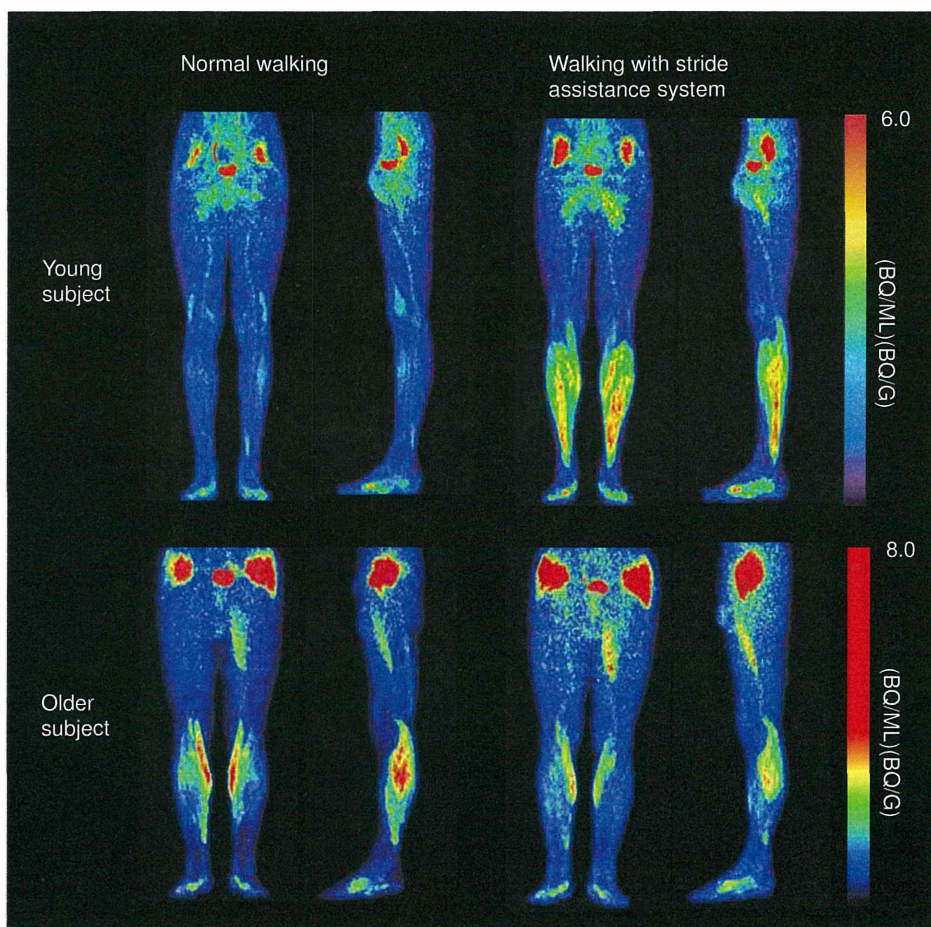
FDG PET images taken after walking without or with the SAS. The left and right panels show projection images taken after walking without or with the SAS, respectively.
